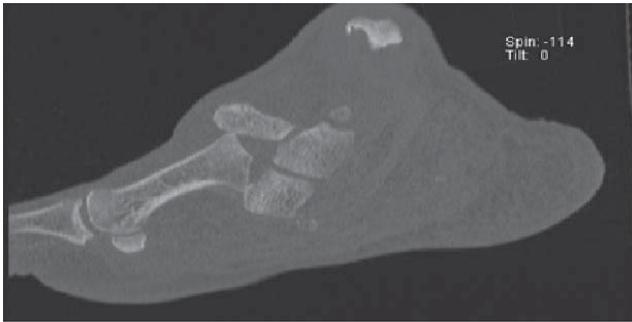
CT-scan of the left foot.
